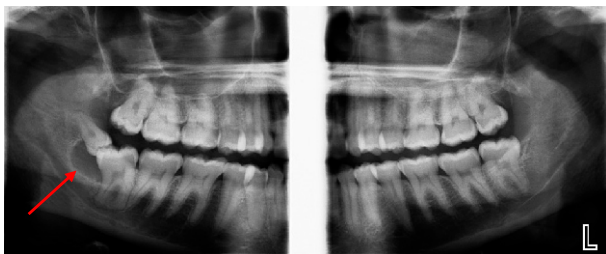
Panoramic radiograph (sectional panoramic radiograph) of 32-year-old male patient with cystic lesion associated with the crown of the mandibular right distomolar and the right mandibular third molar. The thin, smooth sclerotic outline of cystic lesion extends from about 3mm below the CEJ on the distal surface of the distomolar to about 4mm below the CEJ of the adjacent third molar.
